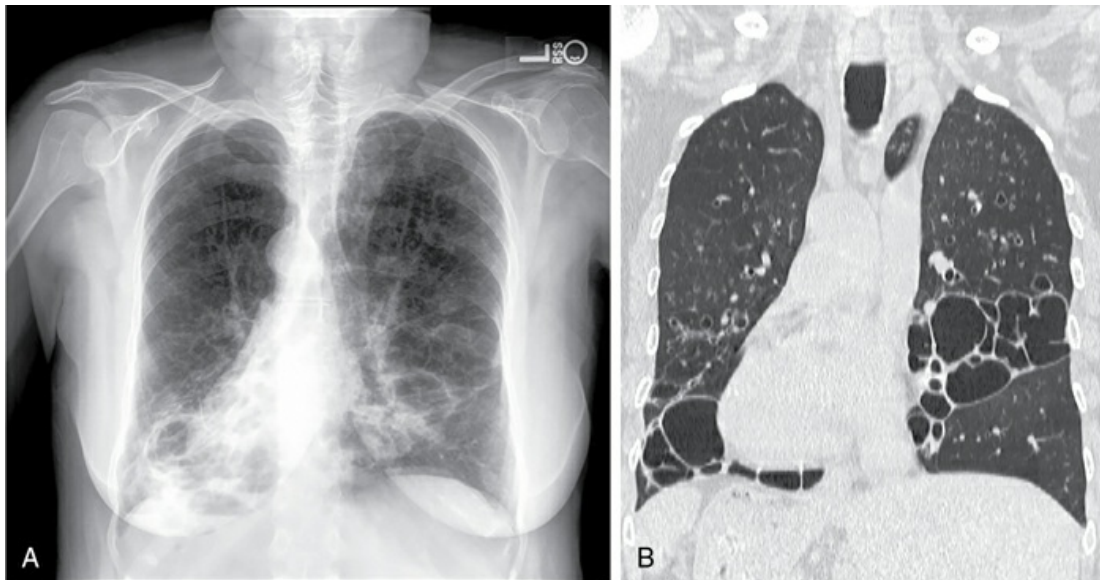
Chest imaging studies from a patient with Kartagener syndrome, showing dextrocardia and bronchiectasis. A, Posteroanterior (PA) chest x-ray. Note the “L” at the top of the image, identifying the left side of the chest and documenting that the heart is on the opposite (right) side. B, Coronal slice from the chest CT scan. In addition to dextrocardia, multiple dilated airways are readily visible. *Source:* (Courtesy Dr. Seth Kligerman.)
